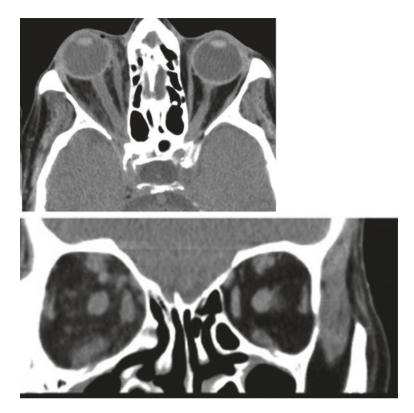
Right orbital mucormycosis. In CT-scan, axial and coronal view, proptosis is absent, and infiltration within the fat is very mild compared to normal side
